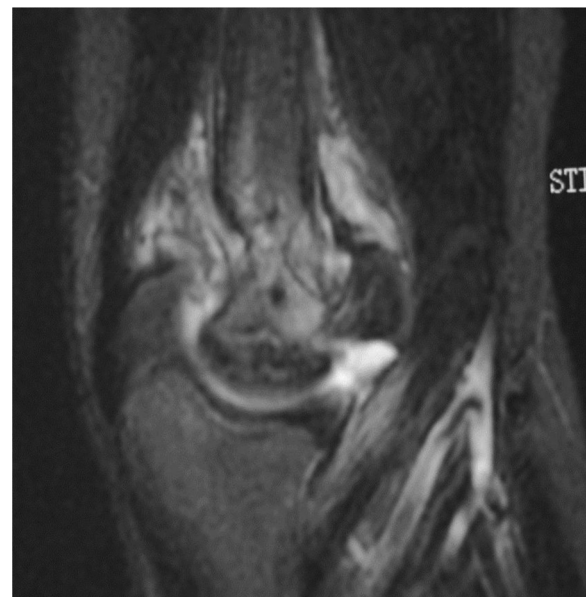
Sagittal short tau inversion (STI) recovery MRI showed a displaced coronal chondral fragment of the trochlea.
